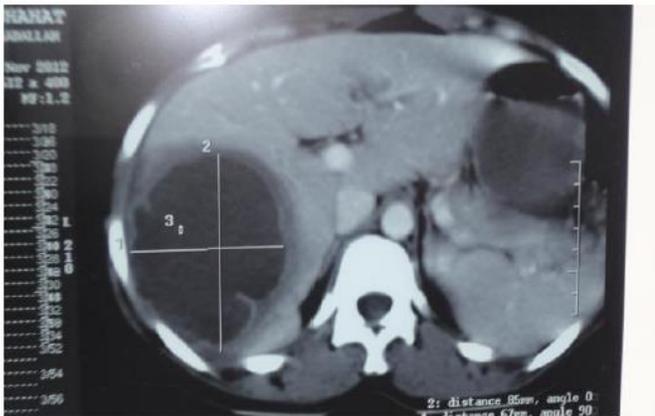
CT scan showing cystic abscess cavity
